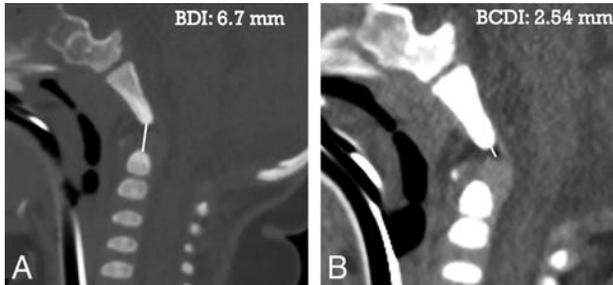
Comparison of BDI versus BCDI in a 6-month-old child. A, Sagittal CT cervical spine image in a bone window shows the BDI as 6.7 mm. B, Sagittal CT cervical spine image in a soft-tissue window shows the BCDI as 2.54 mm.
